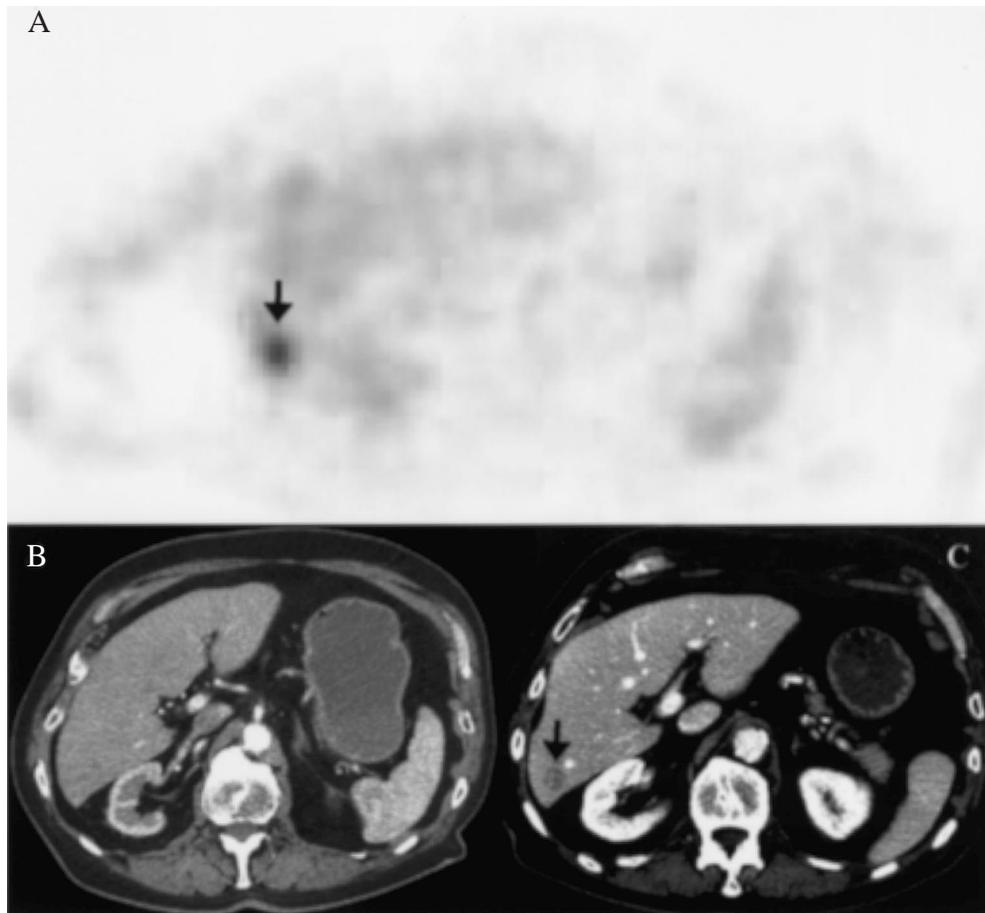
Hepatic metastasis (arrow) detected by FDG PET in the coincidence technique (A) and abdominal CT (C; with portal venous contrast) but missed by the earlier thoracic CT including the upper abdomen (B).
